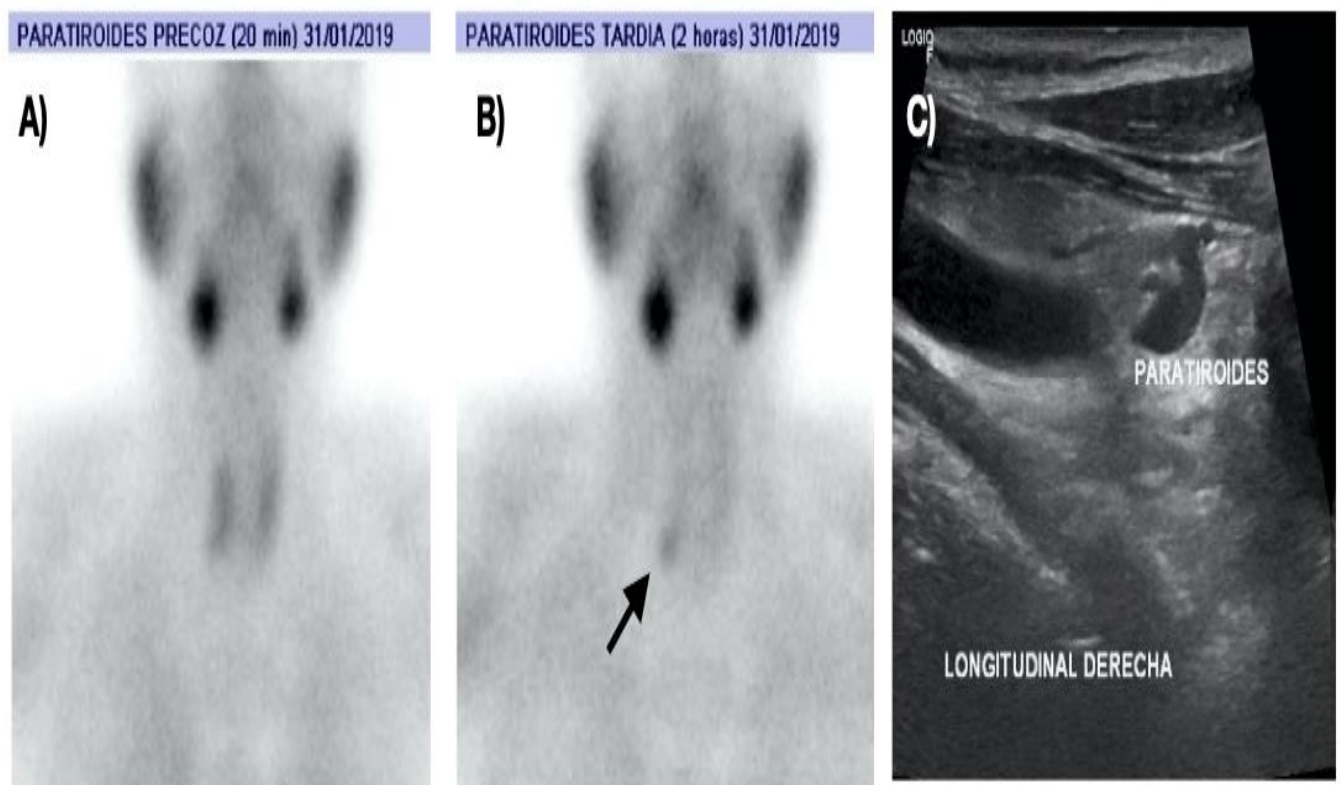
Parathyroid scintigraphy, initial study at 20 minutes (A) and late at 120 minutes. (B) where there is a focal deposit of the radiopharmaceutical, persistent in the late phase, projected onto the lower pole of the right thyroid lobe, indicative of abnormal parathyroid. C) Parathyroid ultrasound: oval and hypoechoic nodule, 5 x 10 mm, behind the lower third of the right thyroid lobe.
